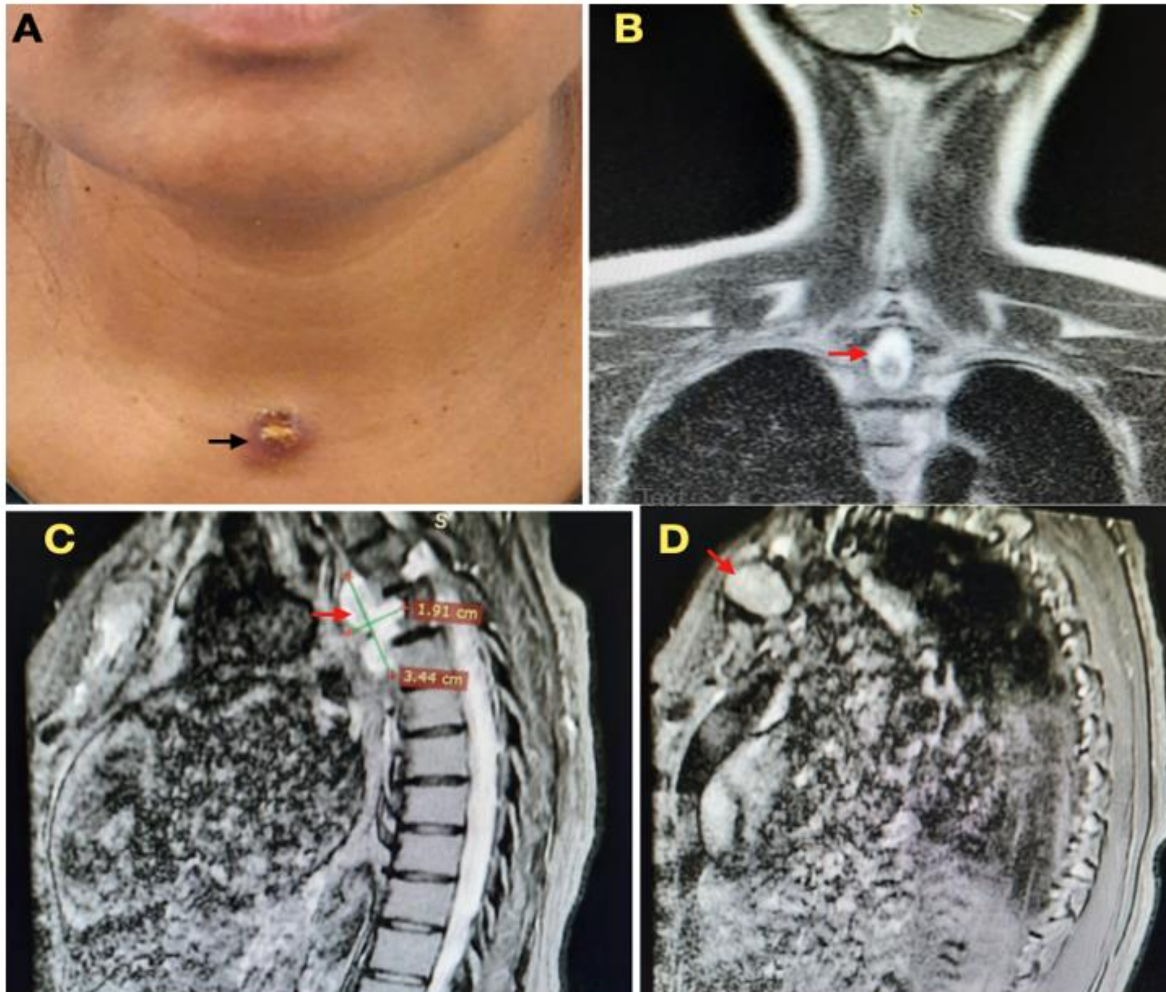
(A). Clinical image showing swelling in front of the neck with a discharging sinus (black arrow). (B,C,D). MRI neck, T2 weighted STIR sequence (B). Coronal view, (C,D). Sagittal view showing hyperintense collection (red arrow) in the neck (B,D) and in the pre vertebral space (C).
